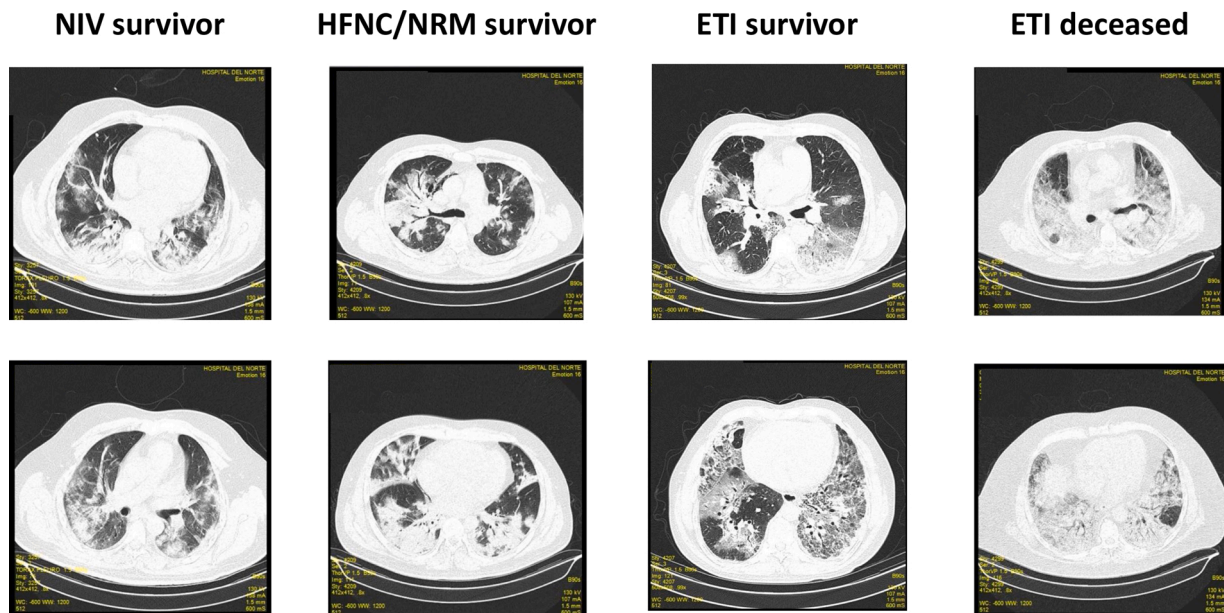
Representative CT scans images comparing lung damage of UCI patients who received non-invasive ventilation (NIV), high-flow cannula/non-rebreather mask (HFC/NRM), and endotracheal intubation (ETI).
